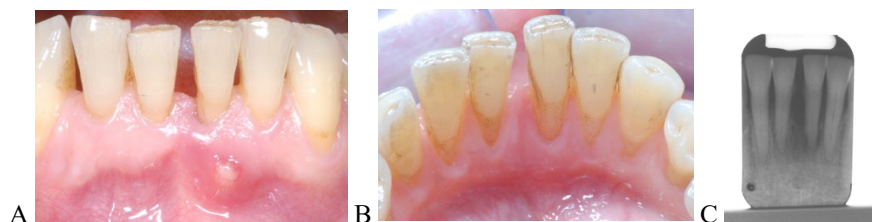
A) Baseline buccal view. B) Baseline lingual aspect. C) Baseline periapical radiograph.*
